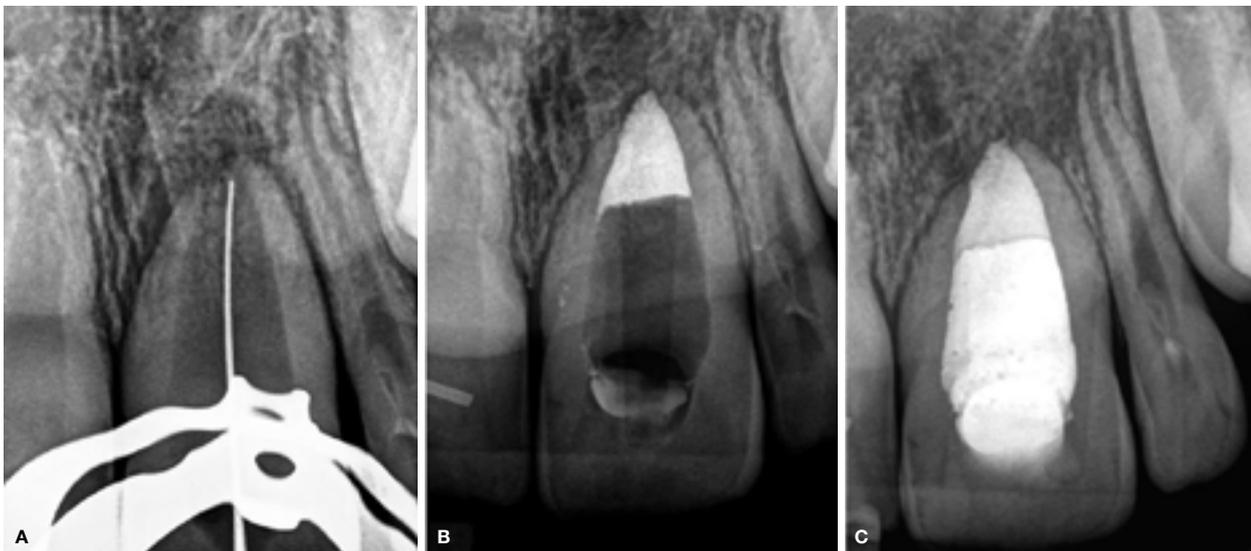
(A) Working length confirmation of the left central incisor on a peri-apical radiograph. Note the size of the root canal compared with that of the size 25 K-File. (B) MTA placed in the lower 4 mm of the maxillary central incisor. (C) Immediate postoperative radiograph after obturation with heated gutta-percha.
